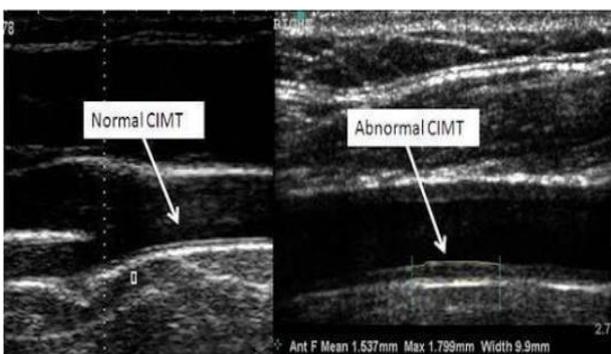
Carotid doppler Showing normal and abnormal CIMT.
